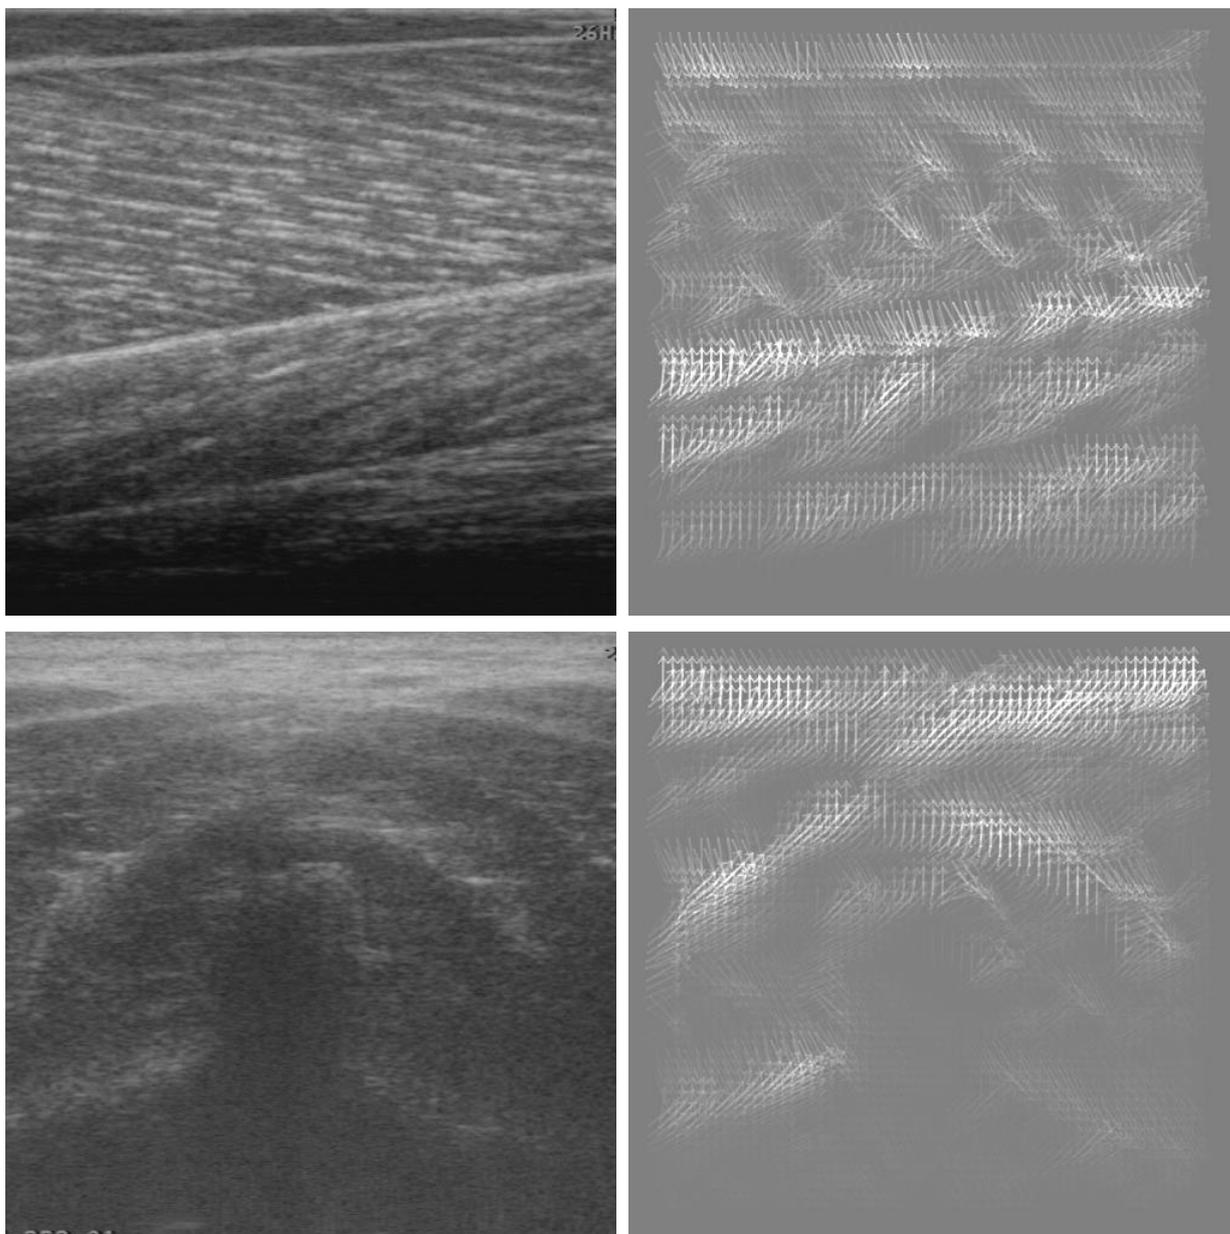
A custom Histogram of Orientated Gradients (HOG) implementation computes a  $64 \times 64$  orientation grid from 90 bin histograms of  $32 \times 32$  image patches. Top: human calf muscles. Bottom: human posterior neck muscles. The image on the left shows the original ultrasound. The image on the right shows the orientation vector field, where the arrow indicates the direction of local gradients, and the intensity of the arrow indicates the magnitude of the local gradient. This project was abandoned due to development of other techniques, and due to difficulty in obtaining enough labelled data, with which to train a multi-class Support Vector Machine (SVM) to classify regions of the image.
